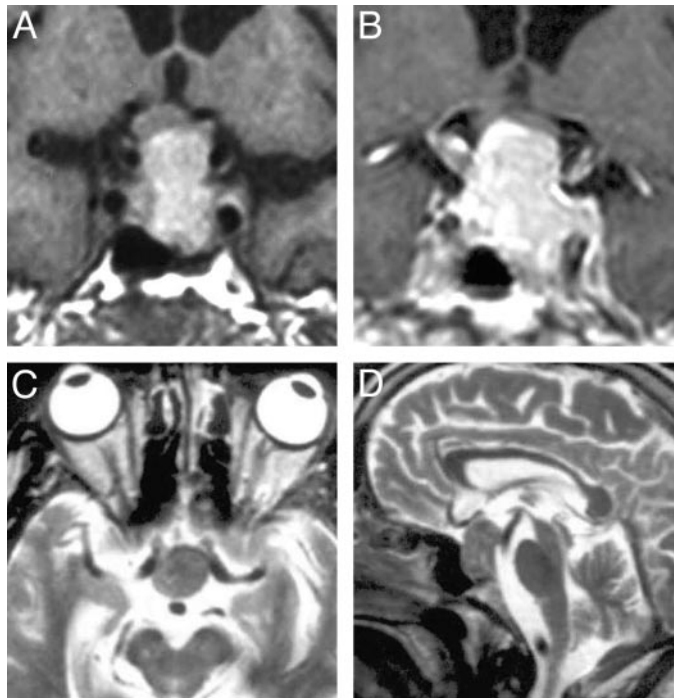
A, Precontrast coronal MRI T1WI. B, Enhanced coronal T1WI. C, Axial T2WI. D, Sagittal T2WI showing pituitary mass with suprasellar extension and invasion of the left cavernous and sphenoid sinuses.
